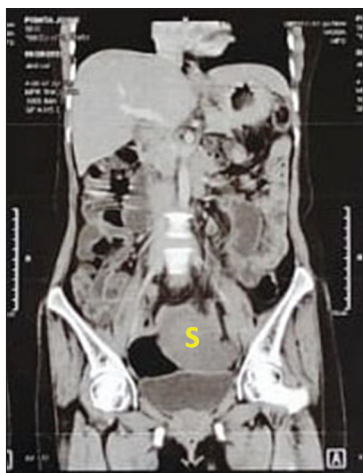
Computed tomography scan in coronal plane defining infarcted wandering spleen in pelvis (S: Spleen)
